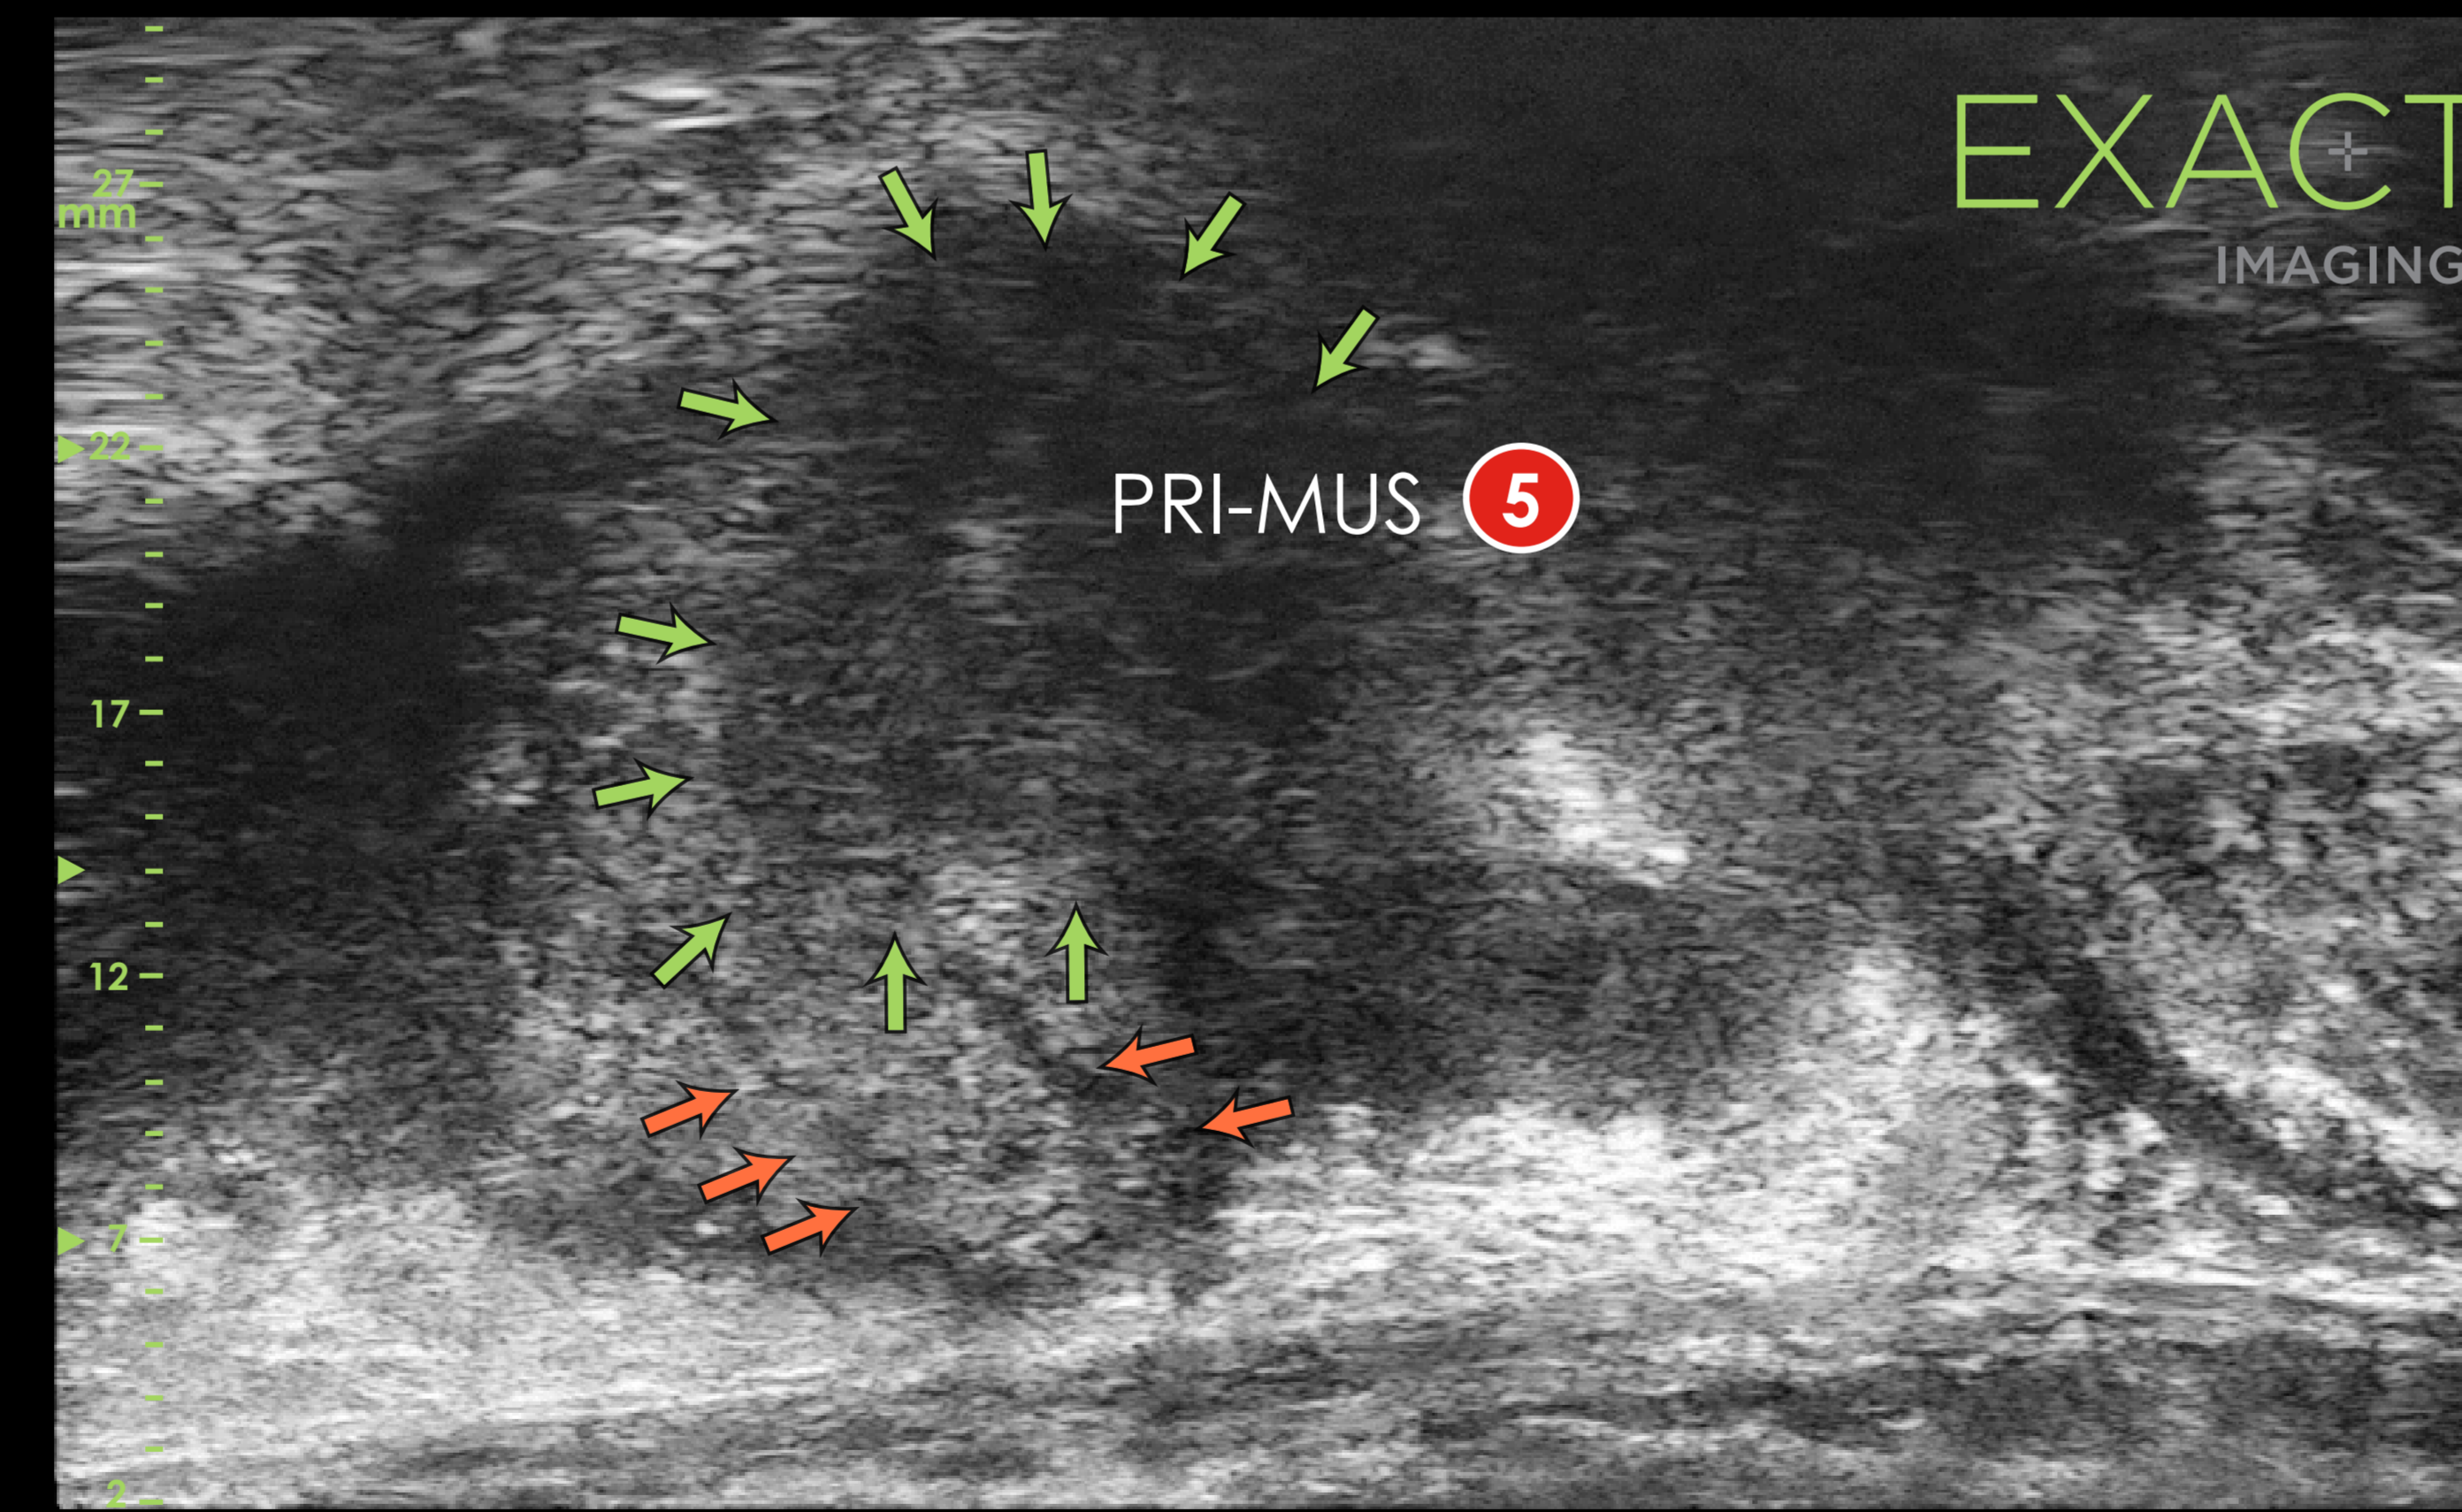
Micro-Ultrasound image of PRI-MUS 5 (suspicious mixed echo lesion). This core was positive on Pathology (GS 7). The lesion is denoted by green arrows, while orange arrows identify 2 prior biopsy needle tracks from 6 months previously. With micro-ultrasound we can see that one of these tracks hit the edge of the lesion, likely resulting in previous GS6 diagnosis.
